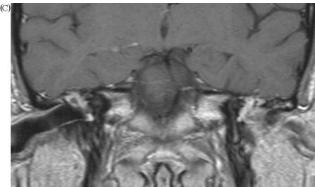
(A–C) Wegener granulomatosis: anacusia on left side, conductive hearing loss on the right. CT (A) shows bilateral opacification within the middle ear and mastoid, no signs of bone erosion. MR T1 (B, before; C, after Gd-DTPA) shows enhancement of the retained material in the left middle ear: granulation tissue. On the right side an hyperintense signal fills the middle ear, consistent with dehydrated fluid collection. Part of the ossicular chain is demonstrated on both sides (arrows)
